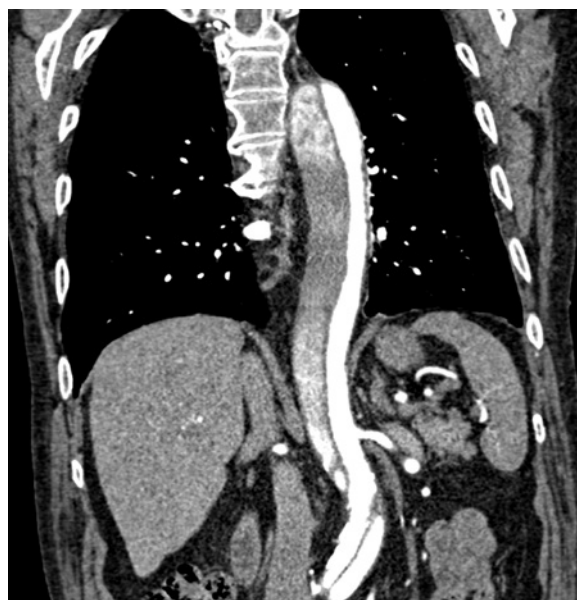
Aortic dissection. Coronal computed tomographic image showing intimal flap in the descending aorta.
